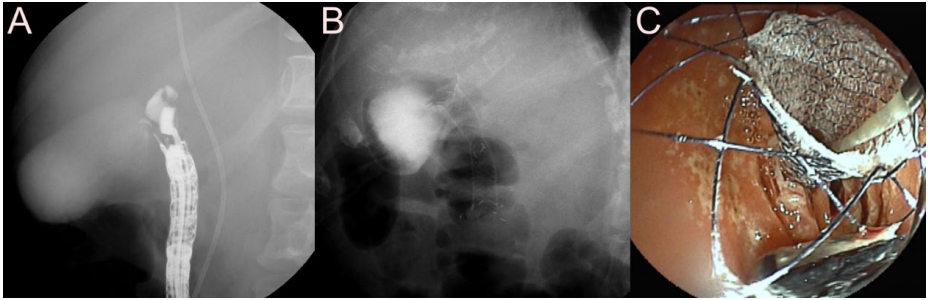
Endoscopic ultrasound-guided gallbladder (GB) drainage using the dedicated bi-flanged fully covered self-expandable metal stent (FCSEMS) (BONA-AL Stent; Standard Sci Tech Inc., Seoul, Korea) for cholecystitis. (A) The GB is punctured using a 19-gauge needle, and the contrast medium is injected. (B) Fluoroscopic images showing the dedicated bi-flanged FCSEMS placed between the duodenum and GB. (C) Endoscopic images showing the drainage of pus-like materials through the dedicated bi-flanged FCSEMS.
